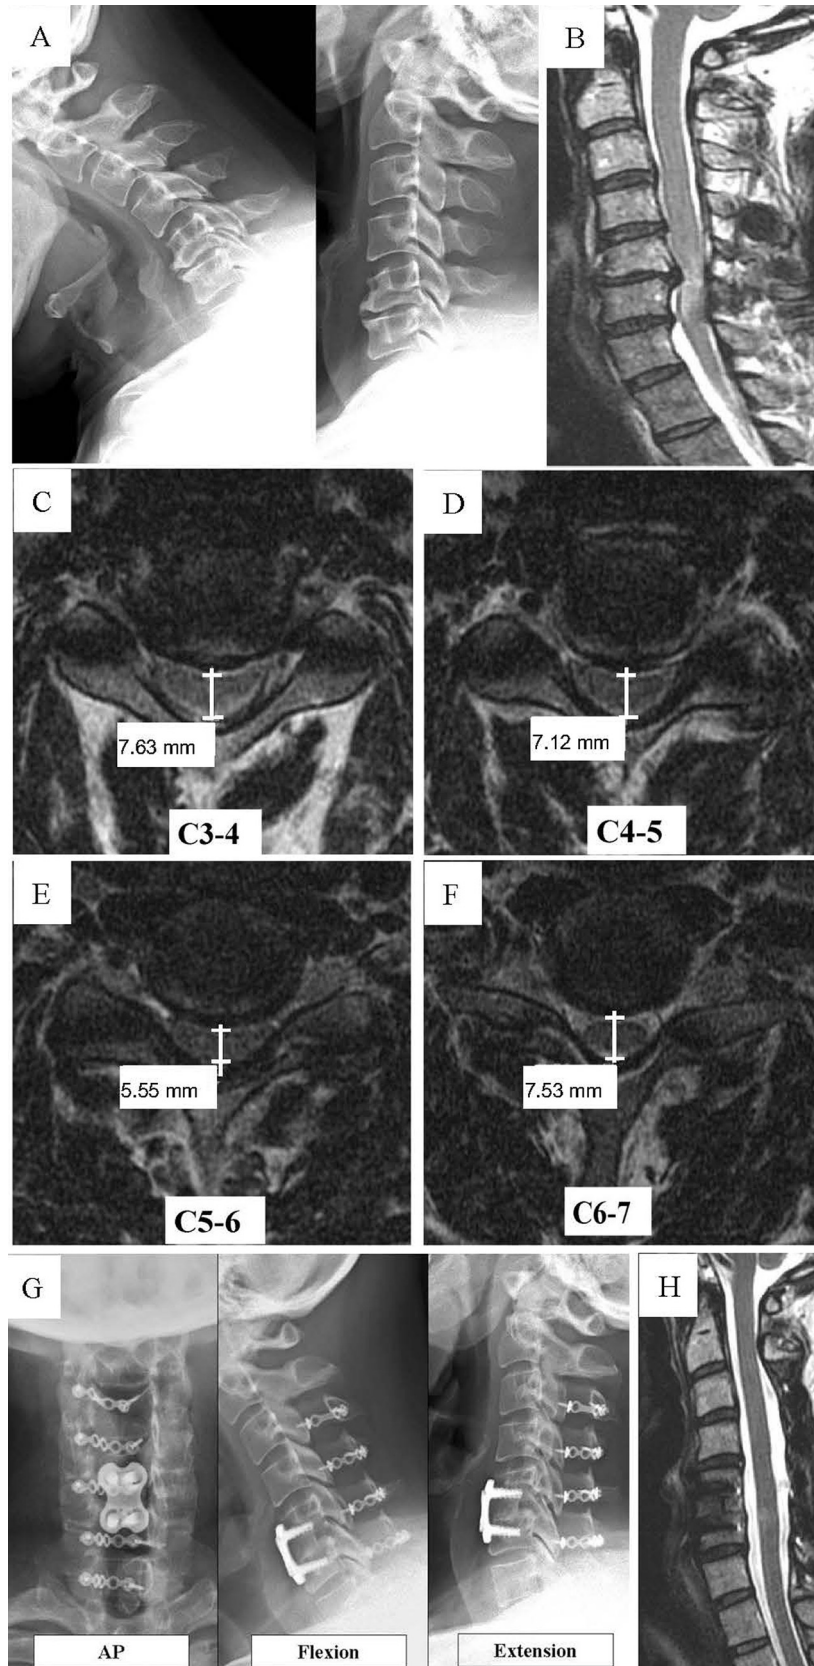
(A) Preoperative radiograph in this case shows C3–4 local kyphosis with spondylolisthesis and (B) T2-weighted magnetic resonance imaging reveals C3–7 stenosis, exhibiting a large C3/4 anterior lesion compression to the spinal cord. Axial cuts of (C) C3/4, (D) C4/5, (E) C5/6, and (F) C6/7, shows the banana shape of the compressed spinal cord, especially C5/6. (G) Postoperative radiograph at 1 month demonstrates improved cervical curvature, and dynamic X-ray at 12 months shows no further collapse and preservation of neck range of motion. (H) Postoperative magnetic resonance imaging reveals patent spinal cord without compression.
